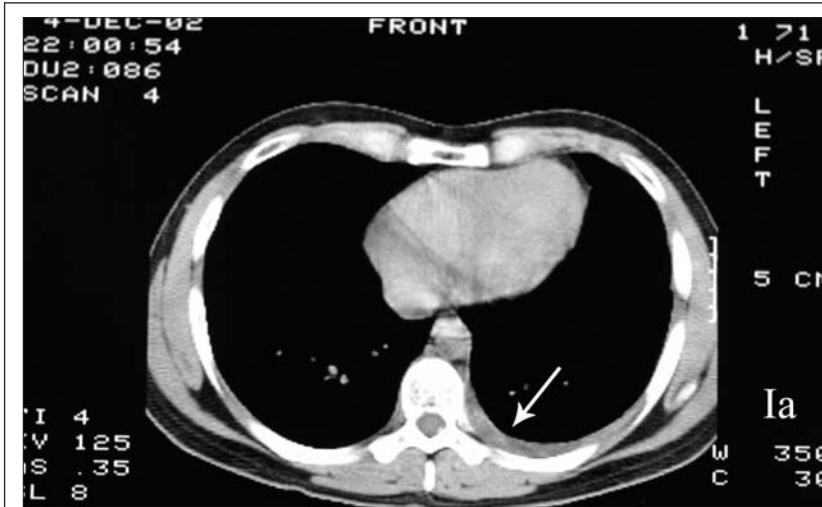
CT scan showing the presence of pleural effusion on the left hemithorax (in 2002).
